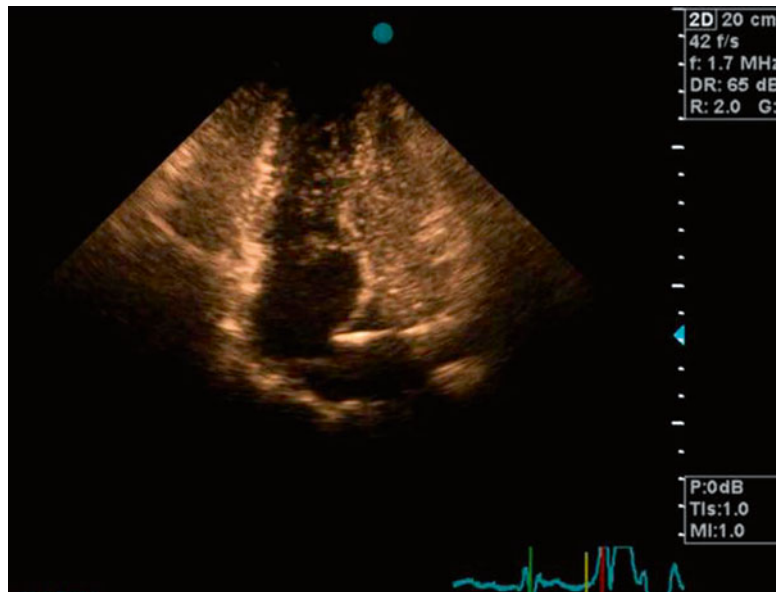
Transthoracic echocardiography in 4-chamber view showing pulmonary venous chamber drains to the morphological RV with no obstruction in 2D study. *RV* right ventricle, *LV* left ventricle
